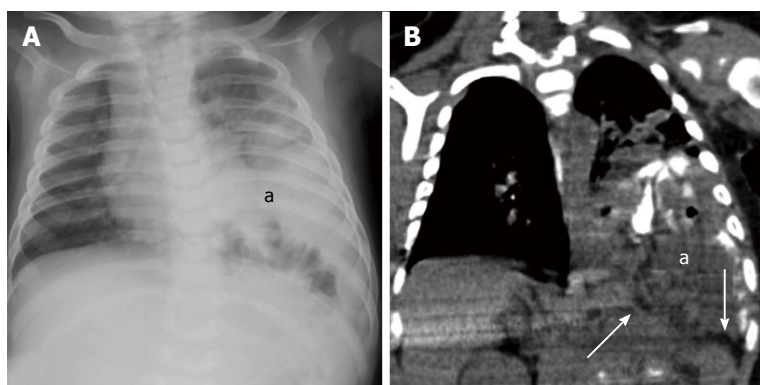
Congenital diaphragmatic hernia. CXR (A) and CT scan (B) of a 3-mo-old patient with congenital left diaphragmatic hernia (a). The diaphragmatic edges are not thickened (arrows). CXR: Chest X-ray; CT: Computed tomography.
